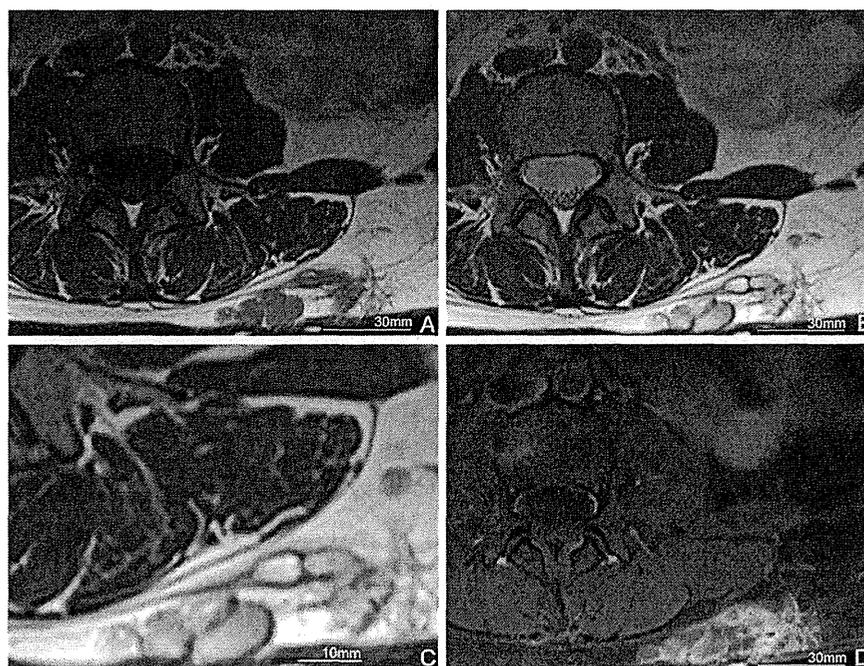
Magnetic resonance imaging (MRI) findings. A. Polycystic mass with inhomogeneous low intensity on T1-weighted image (T1WI). B. The mass with inhomogeneous high intensity on T2-weighted image (T2WI). C. The magnified image of the nodular lesion in B. D. Rim enhancement is seen but the inside of the mass shows no increment of density after contrast enhancement.
